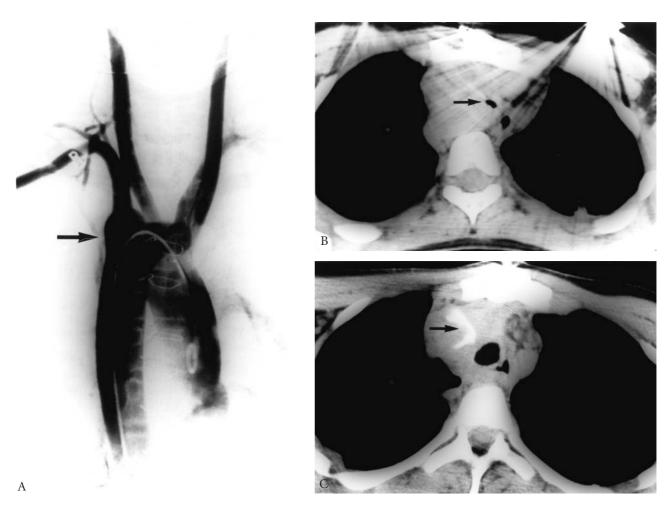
Tracheal obstruction by "hairpin" aortic arch: right aortic arch, right descending aorta, anomalous left subclavian artery originating from aortic diverticulum. A, Aortagram showing a high and narrow arch with a large Kommerell's diverticulum (arrow) from which the left subclavian artery originates. B, Computed tomography (CT) scan showing the trachea (arrow) compressed and displaced by the right aortic arch. Note the short distance between the sternum and vertebral bodies. C, Postoperative CT after aortic bypass, division of arch, and pexy of ascending arch by a Goretex sling (arrow) passed around an anterior rib. The tracheal lumen is widely opened.
